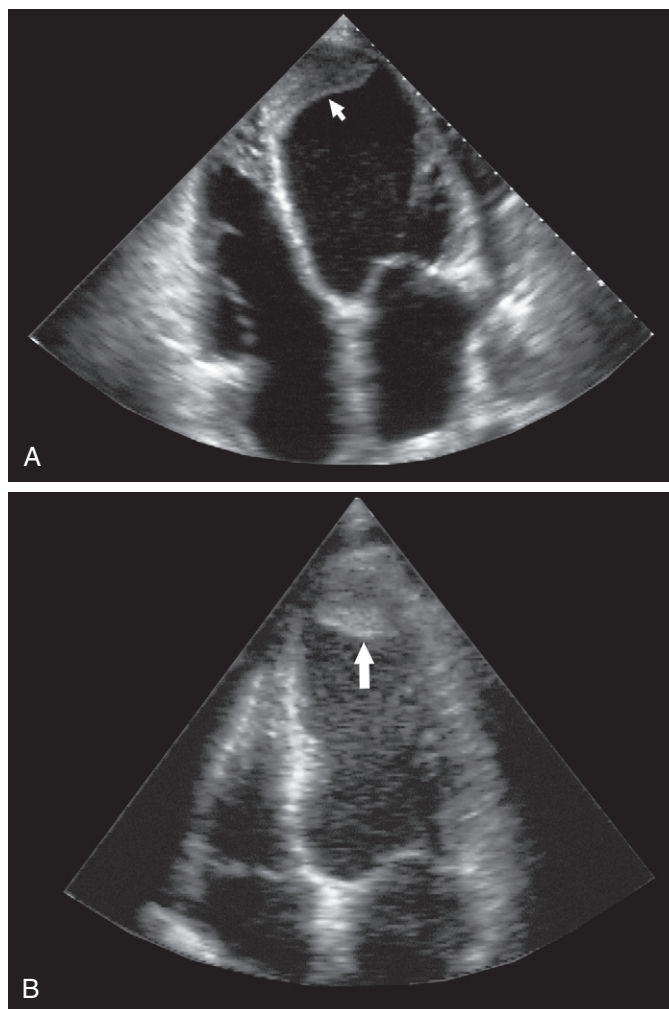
A, B, Left ventricular thrombi in the apical four-chamber view from two different patients. An organized and nonmobile thrombus is detected in the first patient (arrow in A), and a mobile thrombus (arrow in B) is seen in the second patient in a region of akinesia and apical aneurysm. The latter patient suffered a stroke within hours of this echocardiographic examination.
